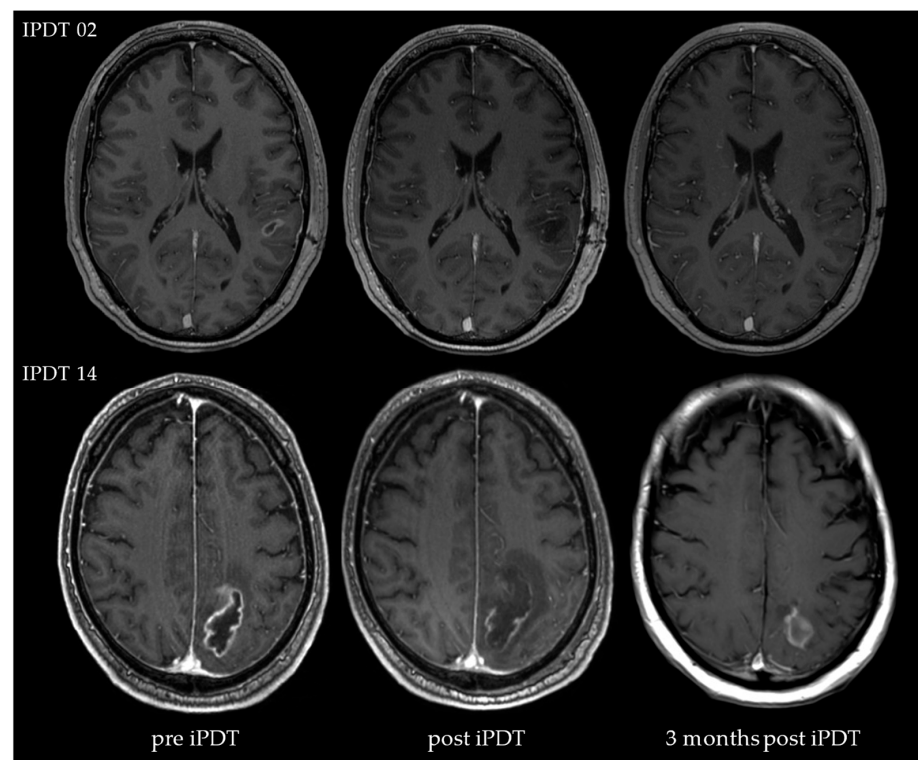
Two exemplary courses of MR images (T1-weighted with contrast agent) recorded before iPDT, twenty-four hours after iPDT, and three months after iPDT (patient IPDT 02 and IPDT 14).
